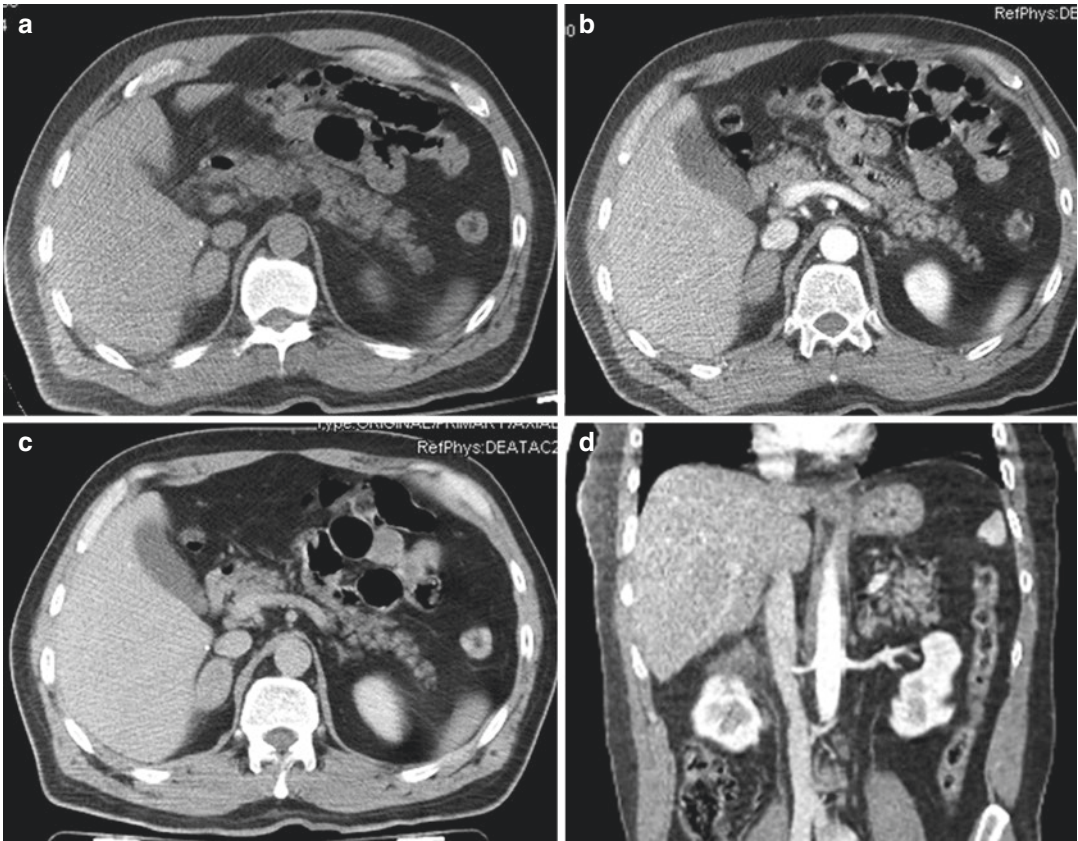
Differential diagnosis in case of incidentaloma in trauma patient. (a–d) CT shows an enlarged adrenal gland slightly hyperdense in basal phase which does not enhance in contrast phase
